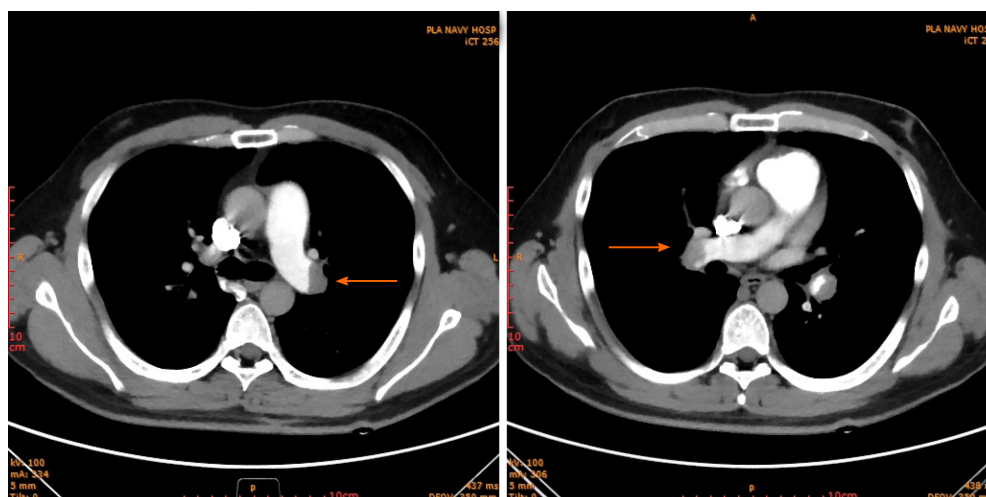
Computed tomography angiography confirmed bilateral pulmonary embolism.
